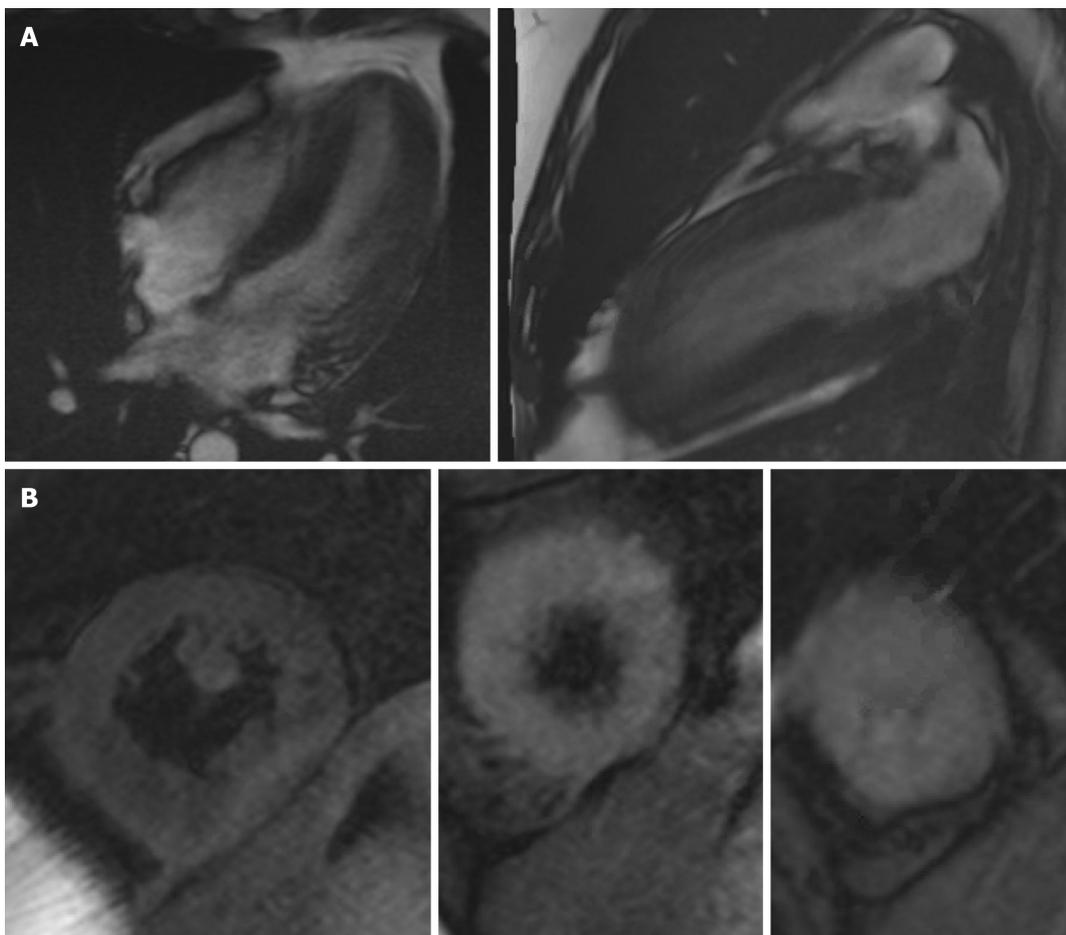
Cardiac magnetic resonance imaging. A: 4 chamber cine, 2 chamber cine showing EF of 40% with global hypokinesis; B: T2 Weighted images showing edema in mid and apical segments.
